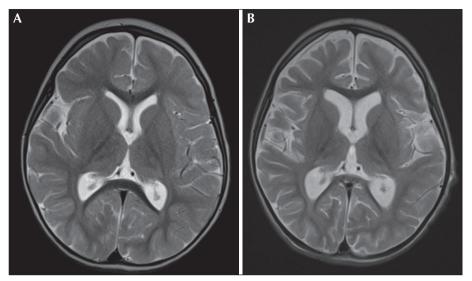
(A) Axial T2-weighed MR image performed at 20 months of age. (B) Axial T2-weighted MR image at age of 31 months showing volume loss.
